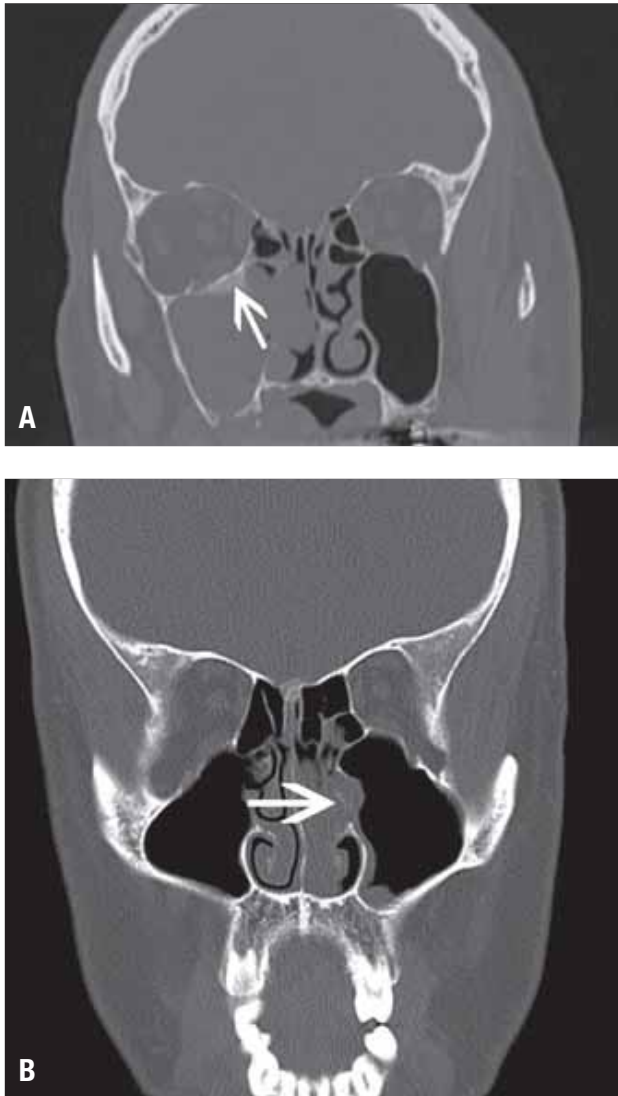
Coronal computed tomogram showing A) Obvious, and B) Subtle, osteitis at the site of attachment of a sinonasal inverted papilloma. Intermediate osteitis is displayed in Figure 2.
